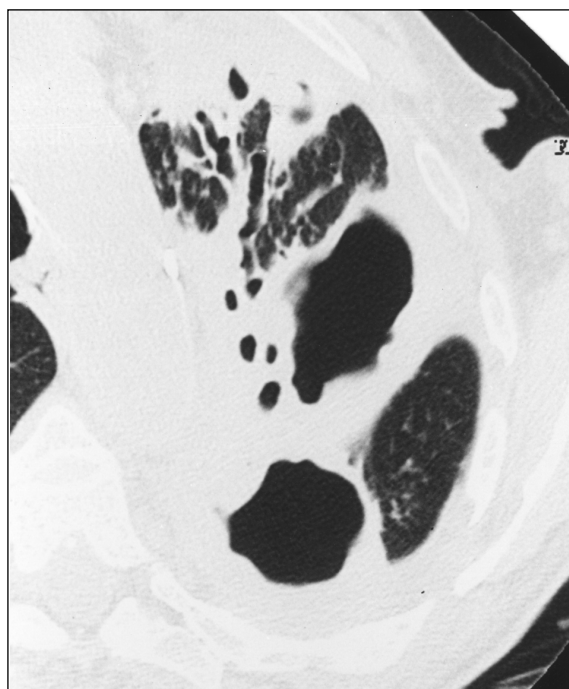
85-year-old woman with pulmonary *Mycobacterium chelonae* infection. High-resolution CT scan of left upper lobe shows two large cavities as well as cystic and varicose bronchiectasis, consolidation, and atelectasis.
